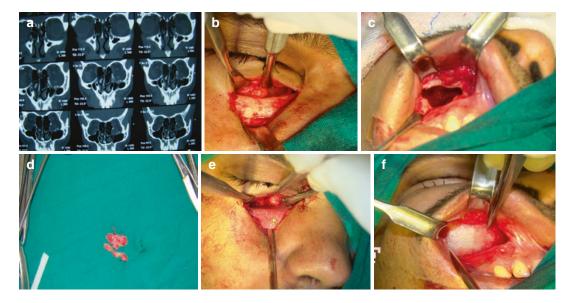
Blowout fracture of orbit. (a) Coronal section CT shows blowout fracture of Rt Orbit. (b) Intraop photo showing entrapment of orbital tissues in the fracture. (c) Tissues cannot be disengaged from the fracture site without further traumatizing. Caldwell Luc approach was used
